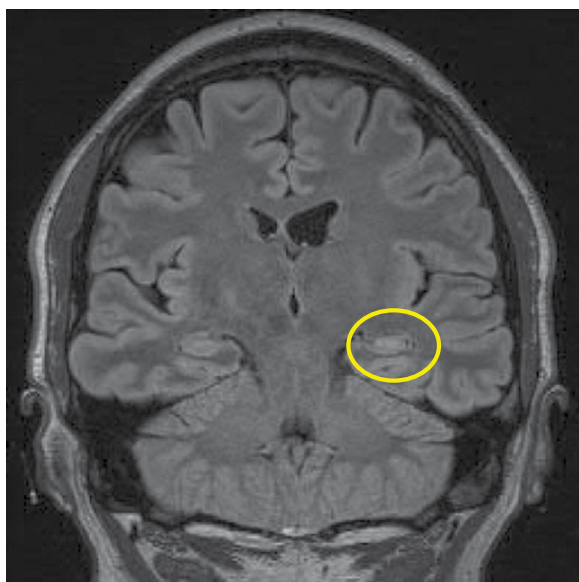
High-resolution brain MRI demonstrating left hippocampal hyperintensity on T2/fluid-attenuated inversion recovery sequence
